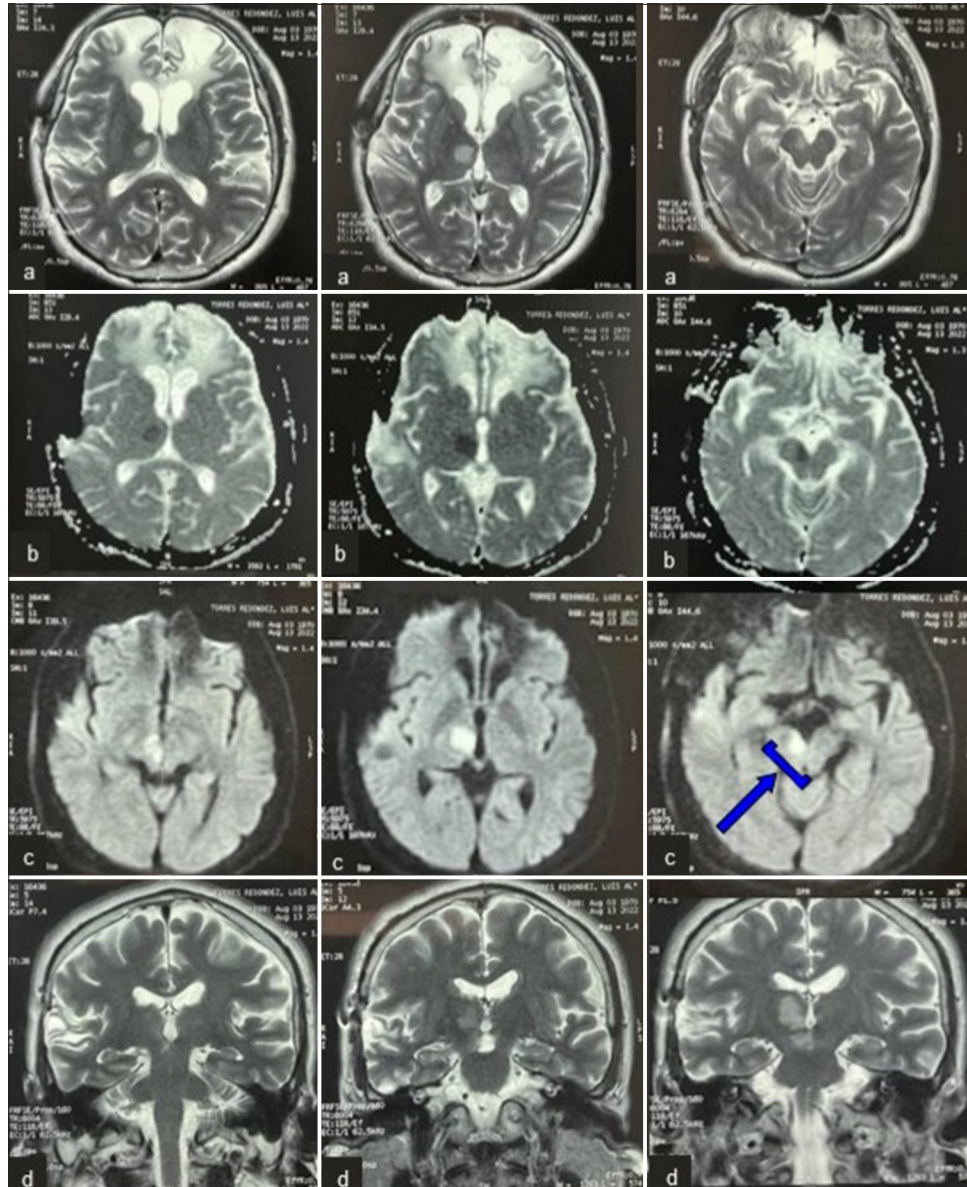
(a) Brain magnetic resonance imaging (MRI). The axial T2-weighted (T2W) image shows hyperintensity in the anteromedial region of the right thalamus, measuring 16×11 mm, and in the paramedian region of the ipsilateral midbrain, measuring 8×7 mm. (b) Low values on the apparent diffusion coefficient (ADC) map and (c) hyperintensity on the diffusion-weighted image (DWI) (blue arrow and bracket) suggests an acute ischemic lesion in both the thalamus and midbrain. This pattern differs from the lesions in the frontal lobes, which are hyperintense on T2W and hypointense on DWI and exhibit high values on the ADC map, corresponding to a chronic lesion due to prior head trauma. (d) The coronal T2-weighted image helps visualize the extent of the hyperintense lesions in the right thalamus and midbrain, consistent with an acute ischemic infarction.
